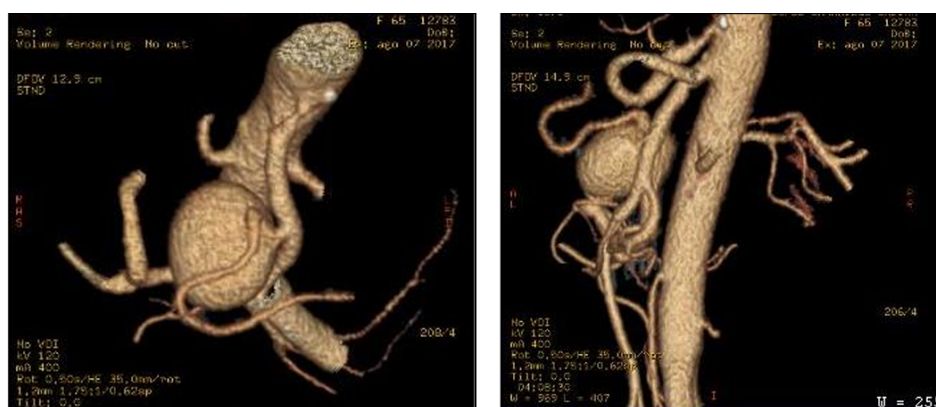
3D Reconstruction CT angiography.
